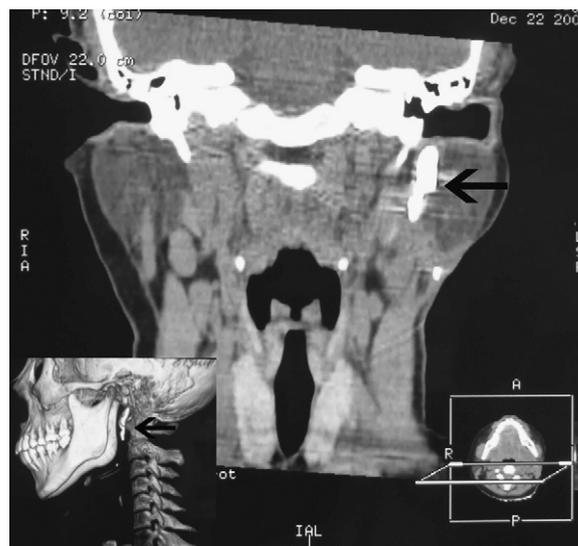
The computed tomogram and CT three-dimensional reconstruction clearly shows that the lesion is close to the external auditory canal and lies deep to the parotid gland (black arrow).
